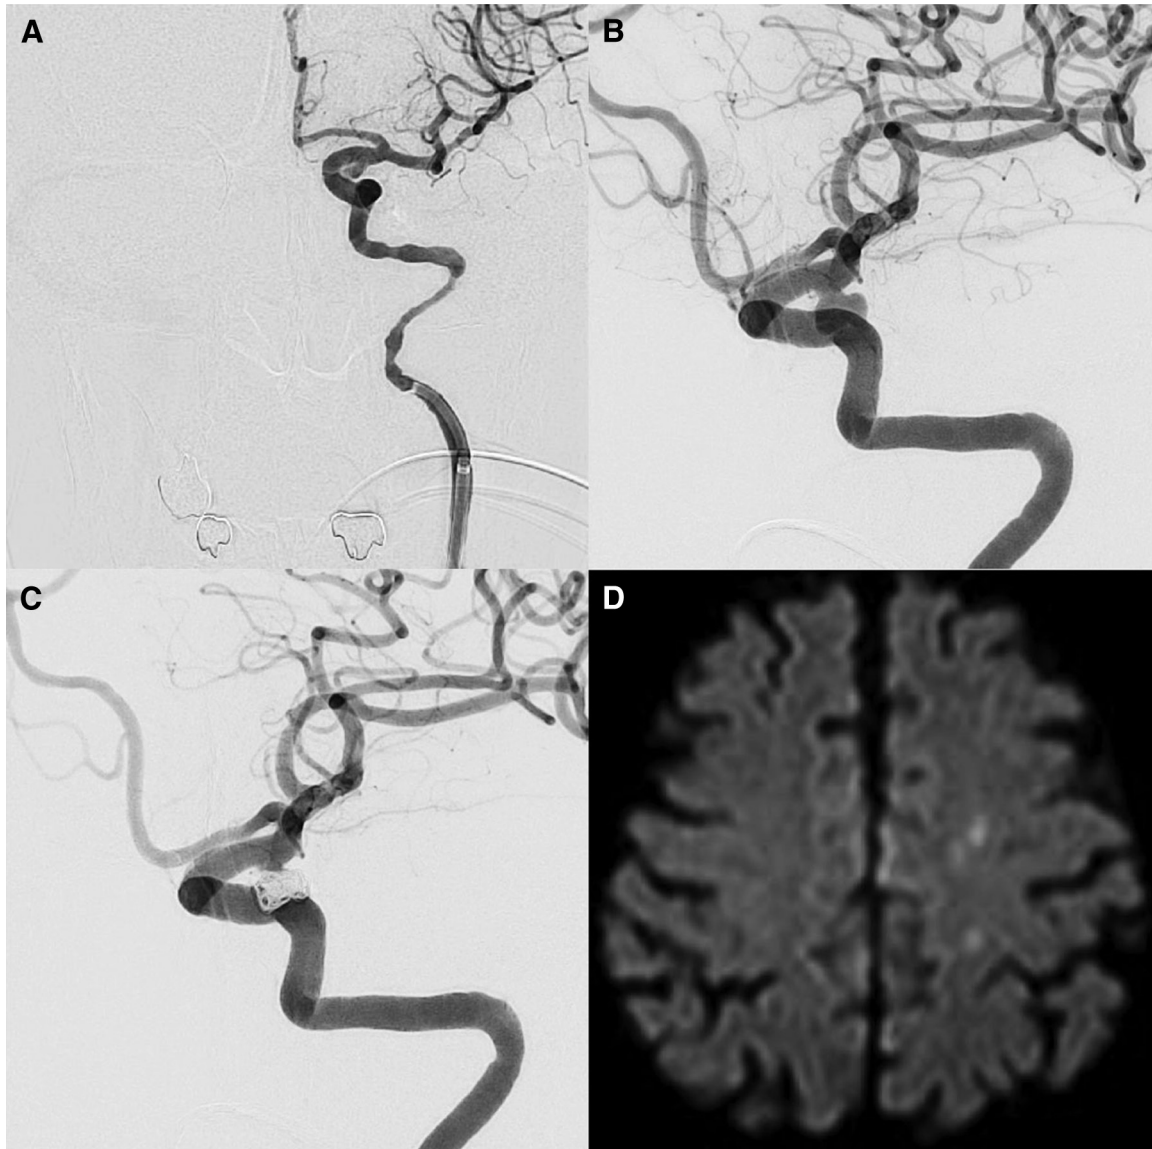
A representative case of mechanical vasospasm and postoperative cerebral infarction. Representative case of a 79-year-old woman with left-sided internal carotid-posterior communicating aneurysm. Test injection of contrast medium showed flow stagnation at the catheter tip, and we had to pull the intermediate catheter down to the level shown in A. Coil embolization was completed without any intraoperative problems (B, preoperative image; C, postoperative image). Postoperative MRI showed seven DWI hyperintense spots, with three of these seven spots shown in D. DWI: diffusion-weighted imaging, MRI: magnetic resonance imaging.
